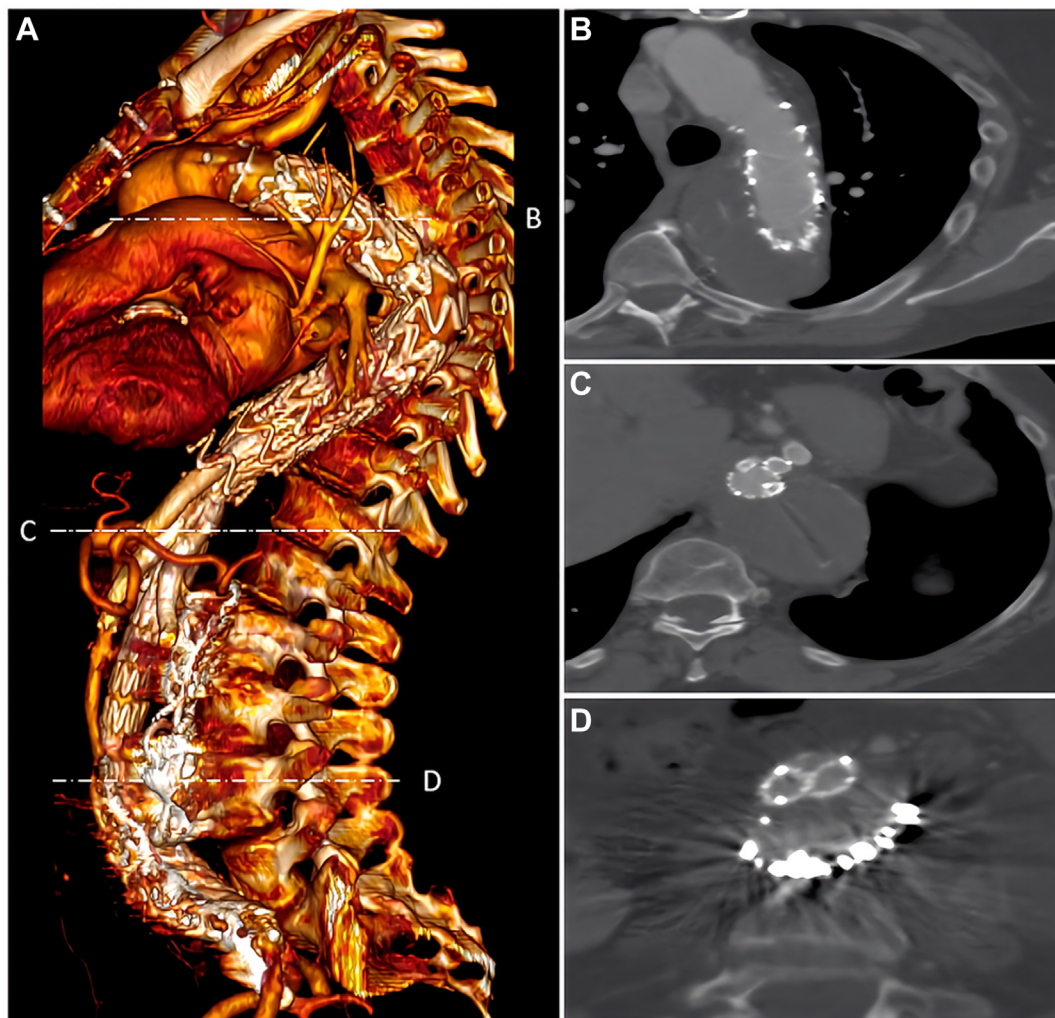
Postoperative computed tomography angiography (CTA) assessment of the aortic topology of the patient. A, Aortic volume rendering reconstruction of the entire aorta; B, Axial section CTA showing aneurysm shrinkage and left lung re-expansion; C, Axial section CTA showing patency of all visceral stent graft; D, Axial section CTA demonstrating patency of the aortic endograft and good embolization of the false lumen.
